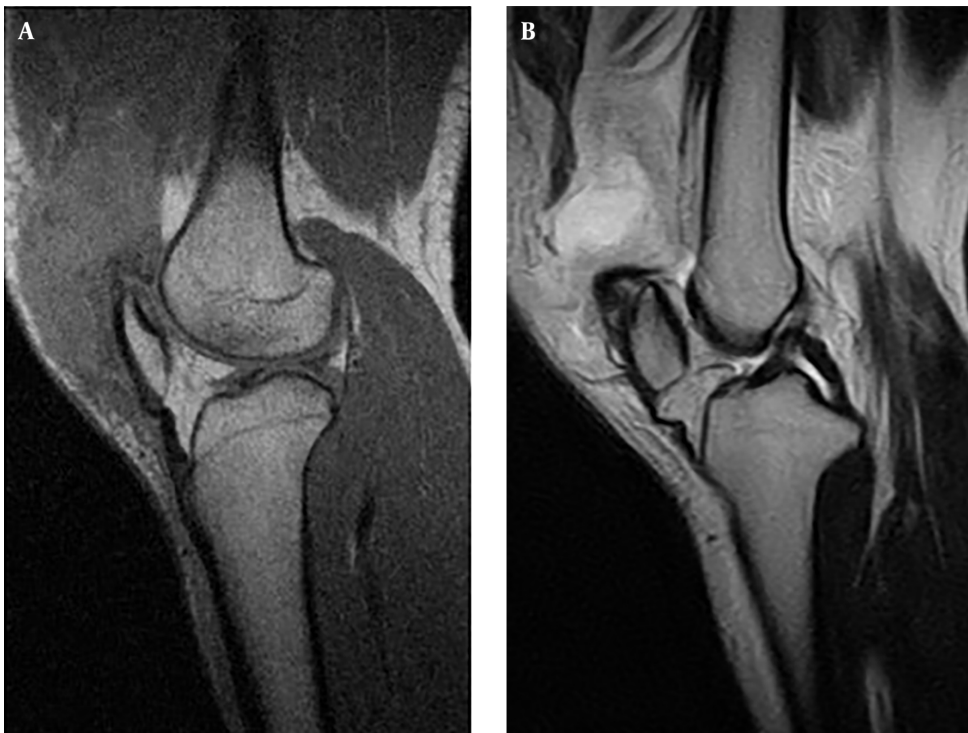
Sagittal T2 - Weighted MRI of (A) Right and (B) Left Knee Showing the Rupture of Quadriceps Tendons of Both Knees from Superior Pole of Patella
